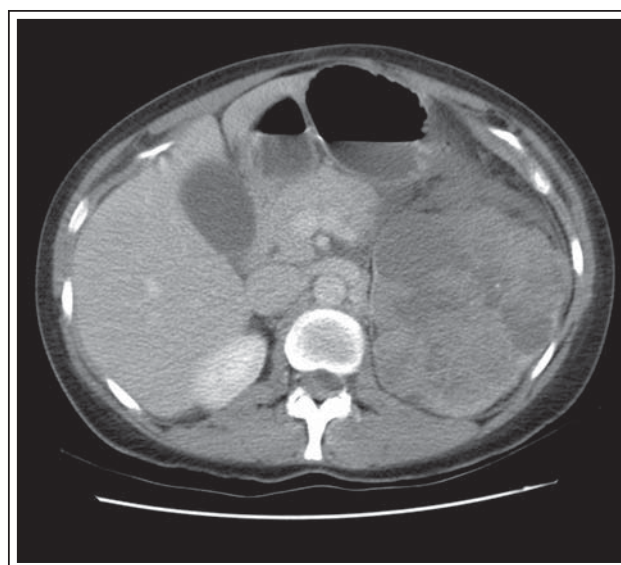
CT scan of kidney showing the huge enhancing renal mass.
